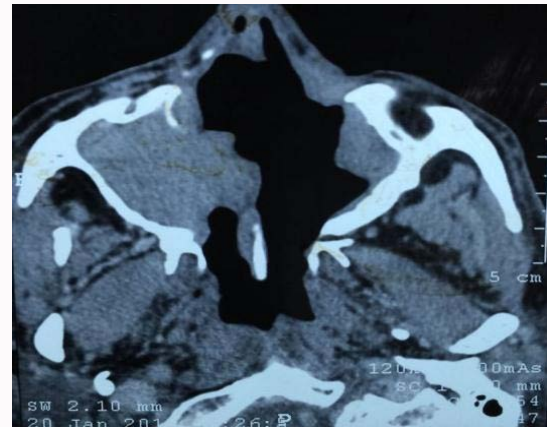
Contrast enhanced CT axial sections showing single nasal cavity with minimal lesion along lateral nasal wall and maxilla.
